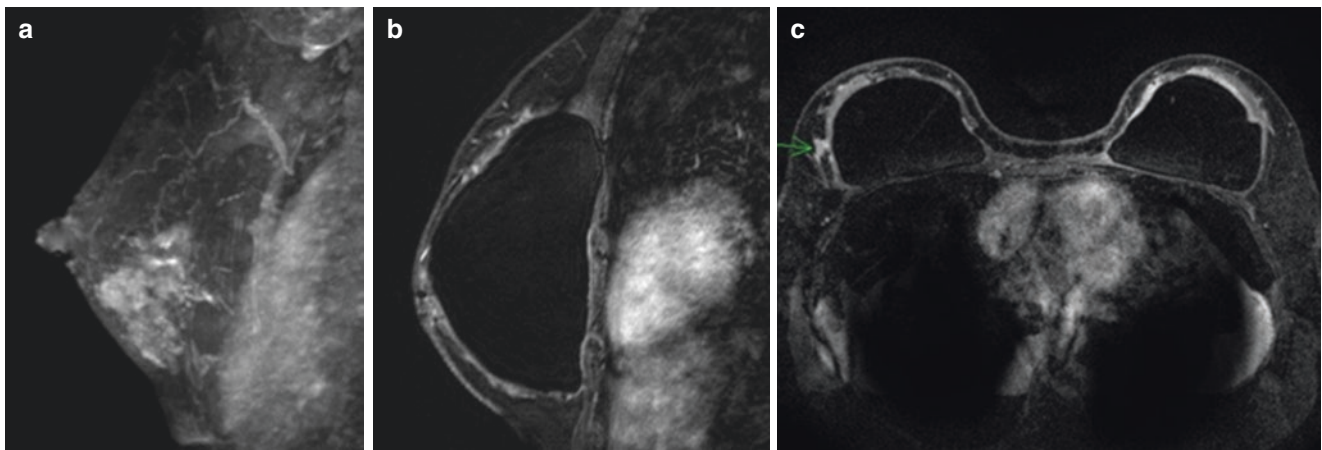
Use of MRI in patient selection for skin-sparing mastectomy. (a) MRI showing extensive mass enhancement in close proximity to the skin in the lower pole of the breast. (b, c) MRI post-skin-sparing
